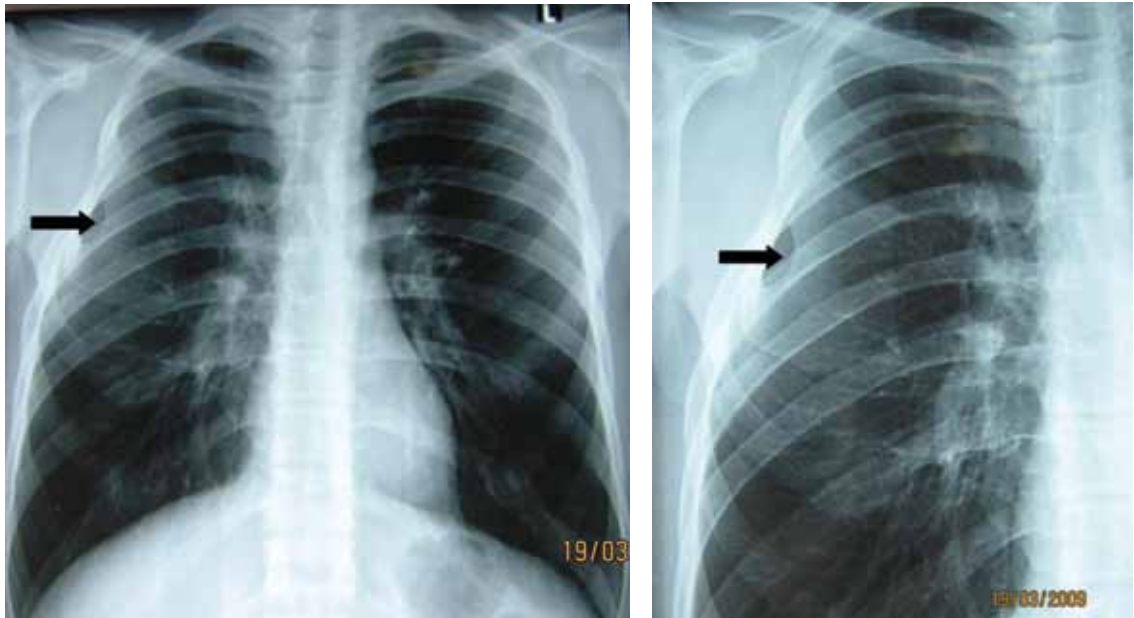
The anteroposterior chest x-ray (left) shows a 1-cm-wide bony bridge (arrow) between the third and the fourth ribs, anteriorly and on the right. The anomaly is also visible in a close-up view (right) of the right rib cage (arrow).
